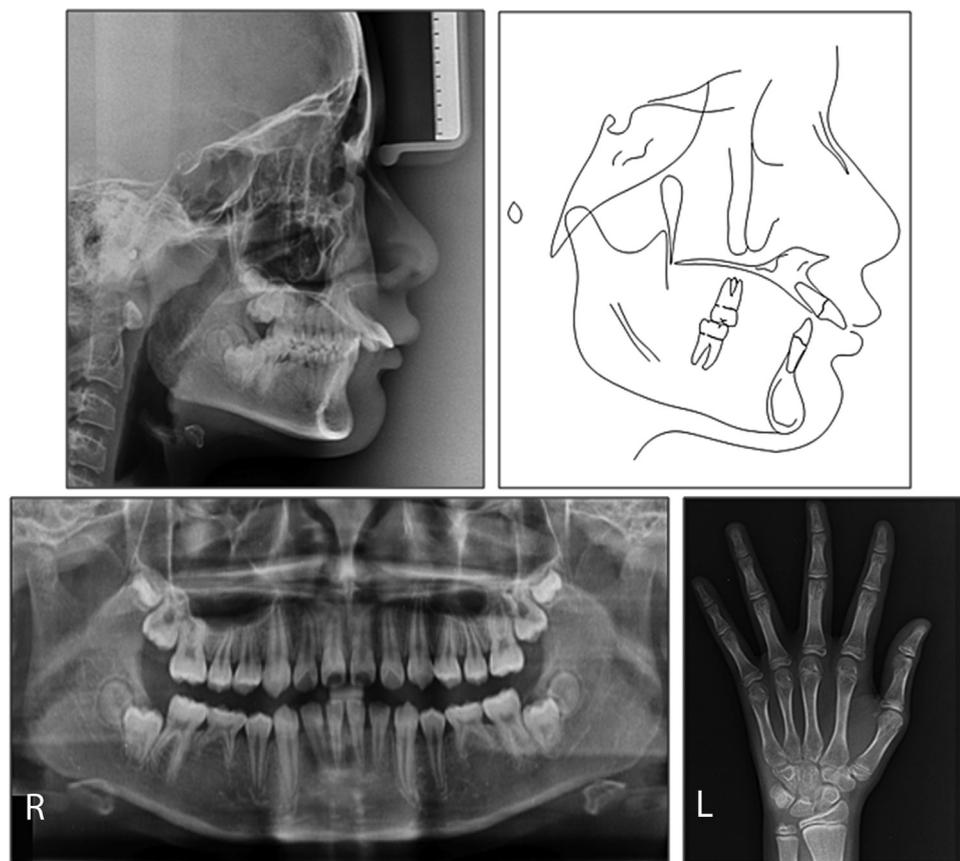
Pretreatment lateral cephalometric, hand-wrist, and panoramic radiographs.
